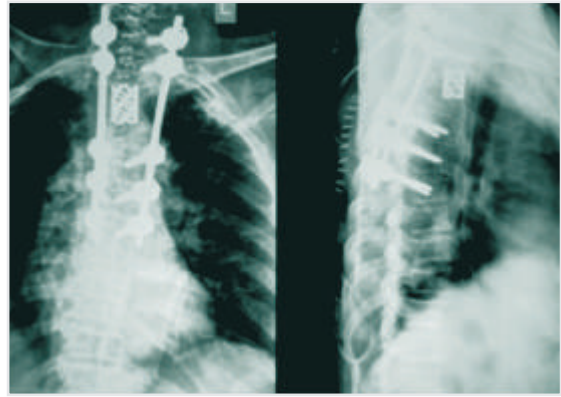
D2 tumour - post operative x-rays
